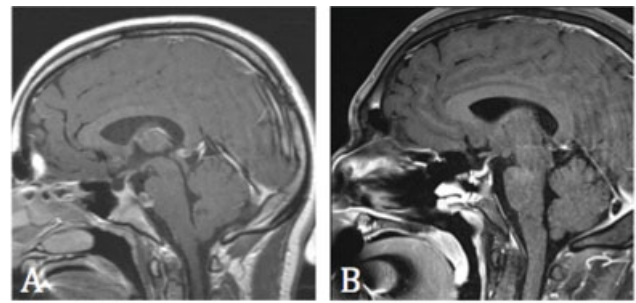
(A) MRI of preoperative chordoma; (B) Postoperative MRI with gross total resection
